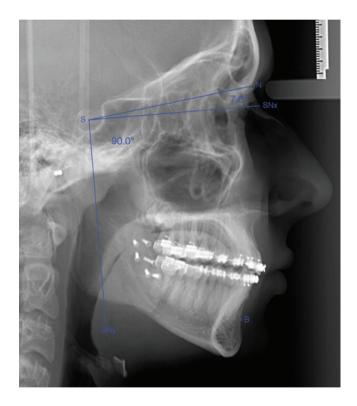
Post-operative lateral cephalometric radiograph shows the horizontal axis (SNx; 7° from sella-nasion line), the vertical axis (SNy) and point B, which were used to determine the stability after BSSO.
